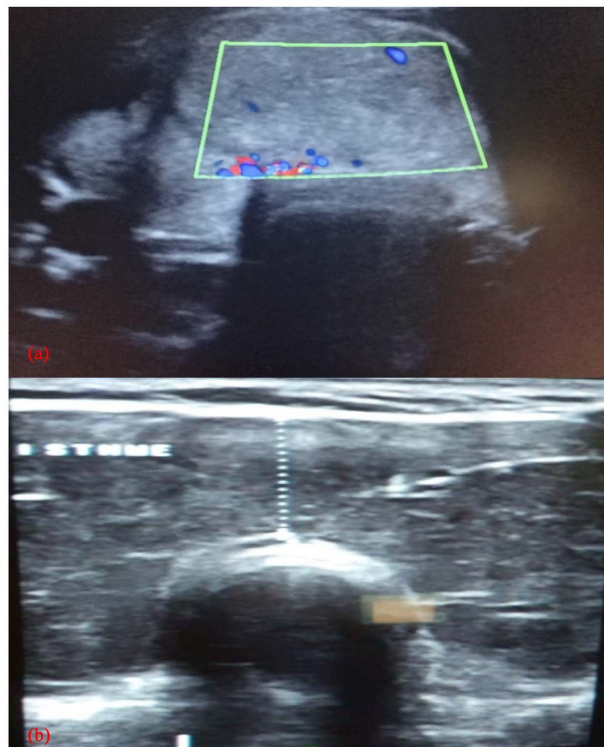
Cross-sectional cervical ultrasound showing a heterogeneous, partially cystic isthmus nodule with poorly defined contours and micro calcifications (a) and a moderately hypo-echoic upper lobar nodule that is fairly well limited with peripheral vascularization on Doppler (b) (examination classified Ti-rads 4).
